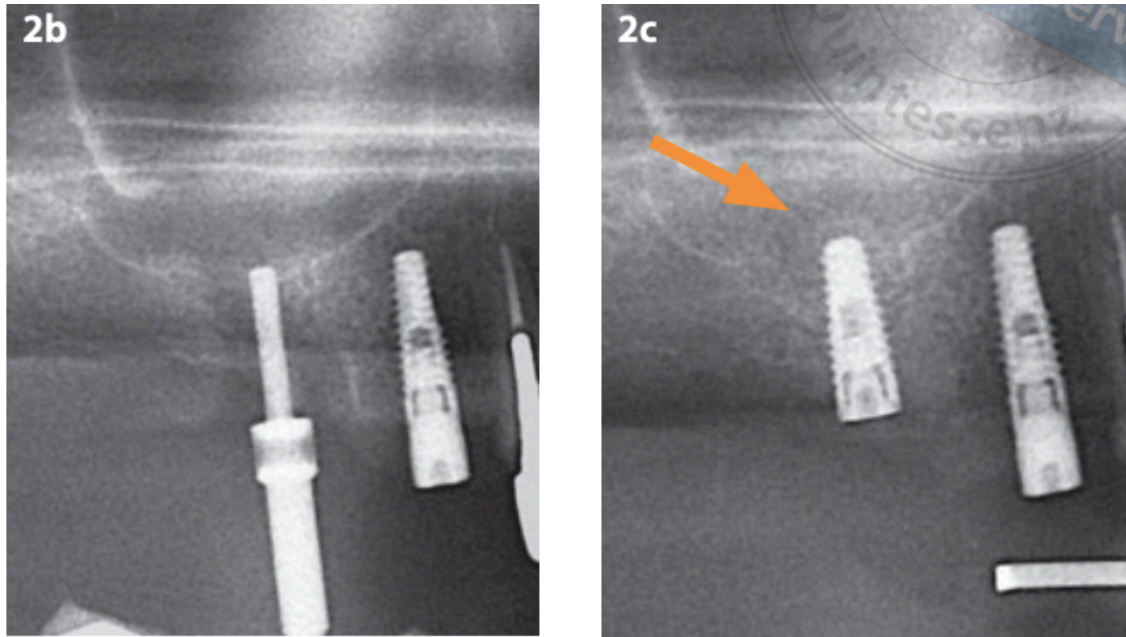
Panoramic radiography highlighting sinus volume (14)
